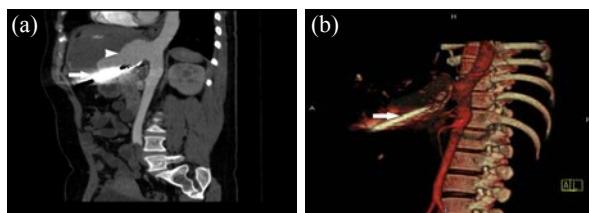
Contrast-enhanced computed tomography (CT) (a) and three dimension reconstruction (b) show pseudoaneurysm (arrowhead) contains a dagger (arrow), which is located between the stomach and liver
